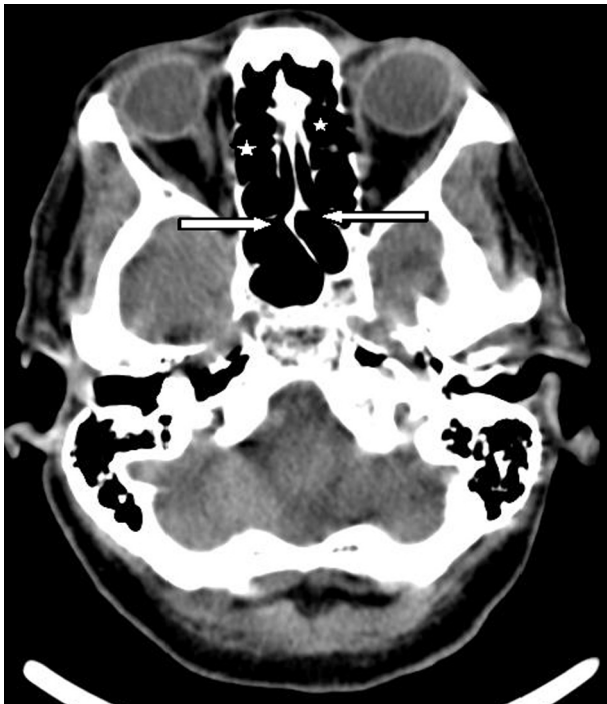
Axial CT image shows the sphenoid sinuses and the sphenoethmoidal recess (arrows), Ethmoidal labyrinths (star).
